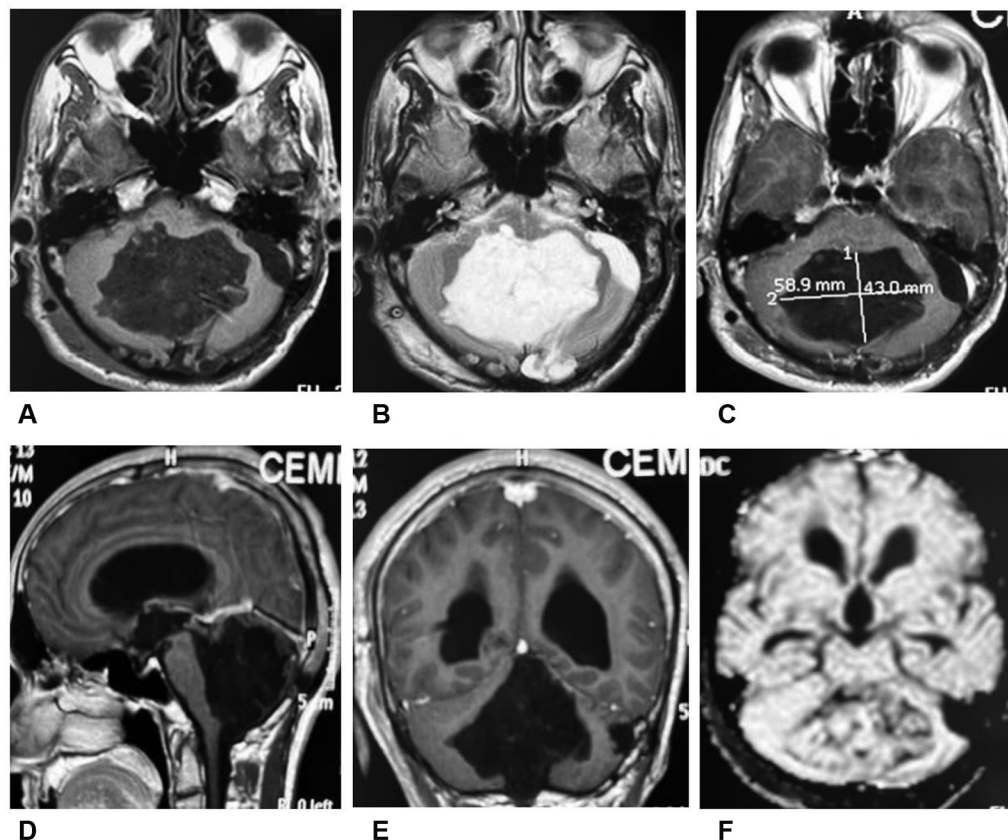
(A) Magnetic resonance imaging (MRI) brain T1-weighted (T1W) axial image showing large hypointense mass lesion filling whole of fourth ventricle. (B) MRI brain T2W axial image showing large hyperintense mass. (C) MRI brain T1 contrast axial image showing no enhancement. (D) MRI brain T1 contrast sagittal image showing tumor filling whole of the fourth ventricle. (E) MRI brain T1 contrast coronal image showing tumor filling whole of the fourth ventricle and insinuating bilaterally into foramen of Luschka. (F) MRI brain with diffusion weighted imaging showing minimal diffusion restriction.
